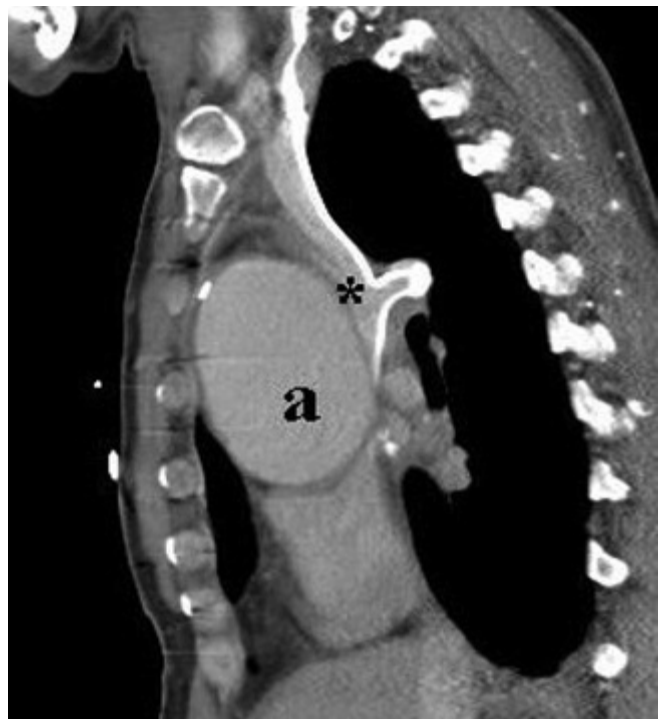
Sagittal reformatting of a computed tomographic scan showing aortic dissection (a) compressing the superior vena cava (*).
